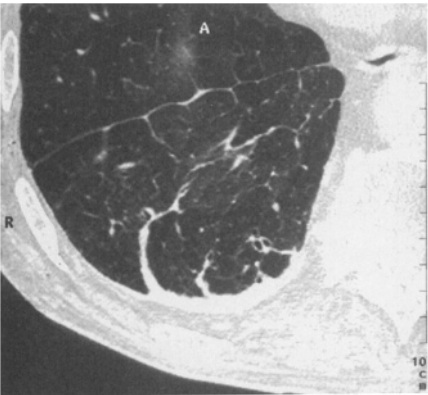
CT scan : visceral pleural thickening with parenchymal bands ; a fissural pleural thickening is also present
